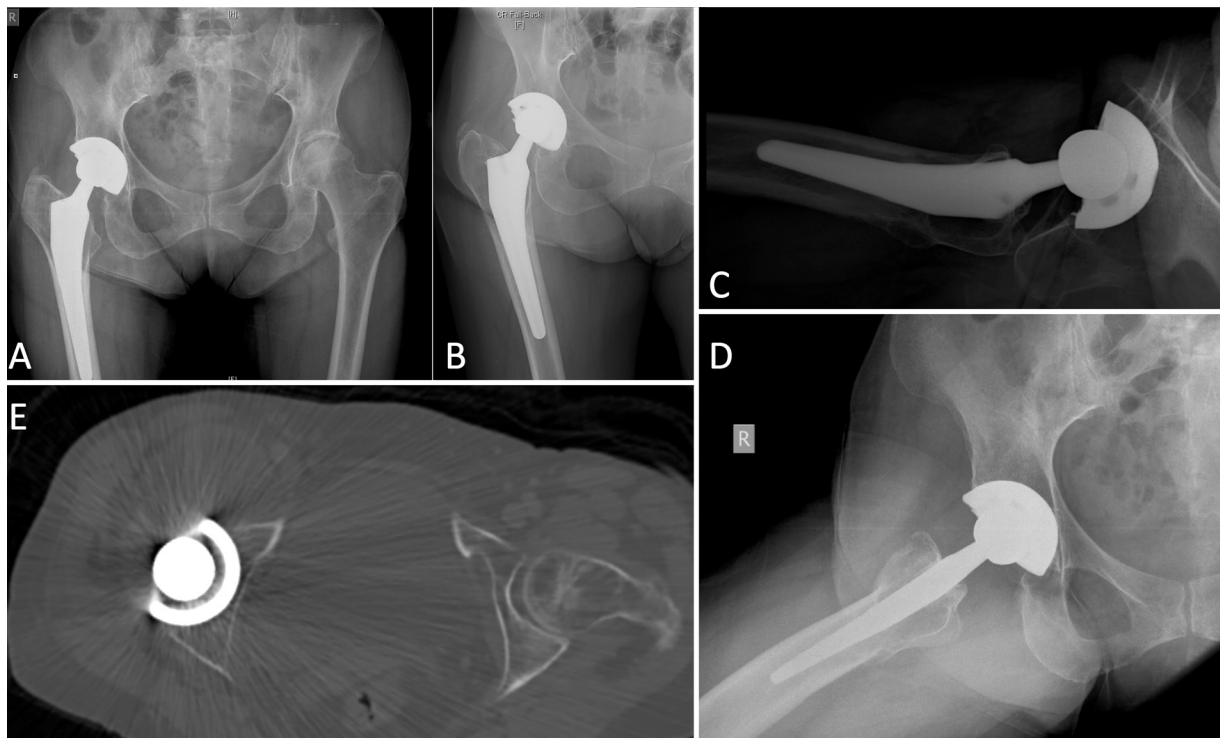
Antero-posterior radiographs (A, B) demonstrate a well-fixed total hip arthroplasty performed for femoral neck fracture. Cross-table (C) and frog-leg (D) lateral radiographs highlight a prominent implant rim, with overhang in the supero-anterior aspect of the acetabulum. Axial computed tomography (E) image 8 years after the index surgery confirms prominence of the prosthetic rim despite appropriate cup anteversion, with resulting large iliopsoas bursal collection.
